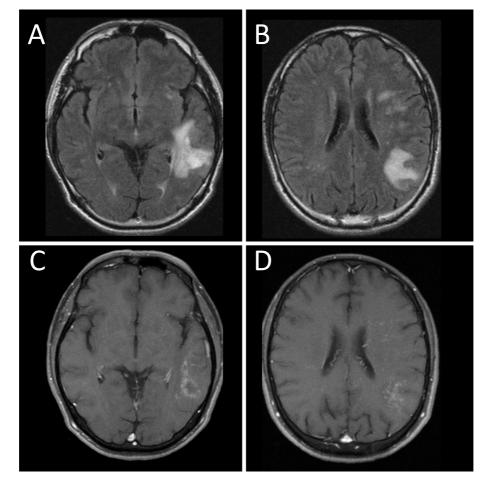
Brain MRI findings at admission. Fluid-attenuated inversion recovery (FLAIR) imaging showed multiple high-intensity lesions in the left parietal and temporal lobes (A, B). Gadolinium-enhanced T1-weighted imaging revealed multiple punctate and linear enhancement (C, D).
